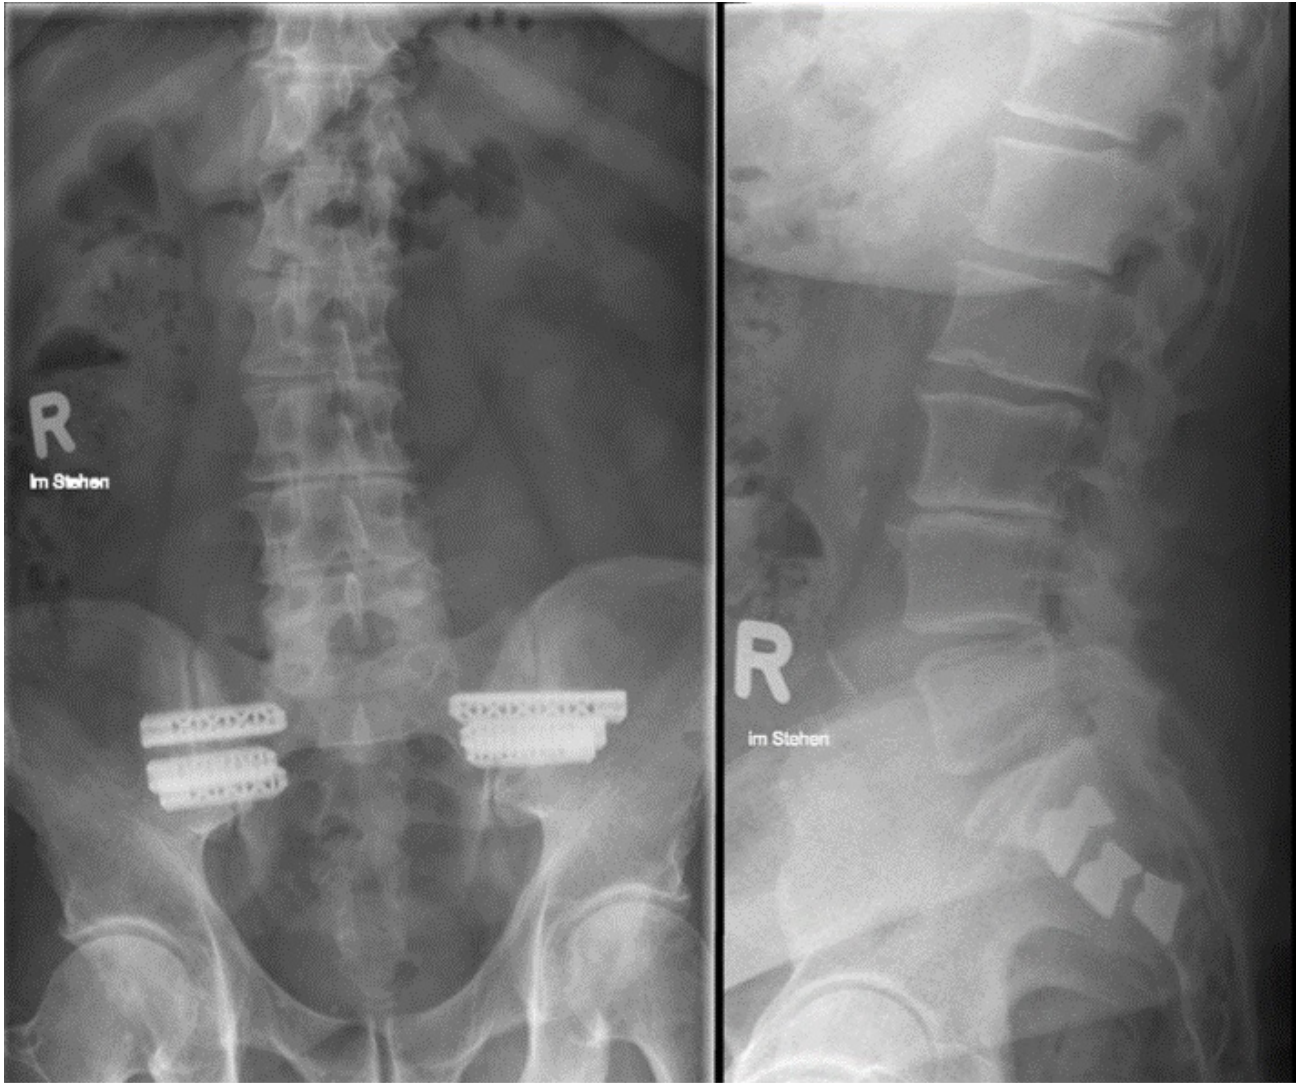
Representative anterior-posterior and lateral X-ray images after minimally invasive SIJ fusion.
